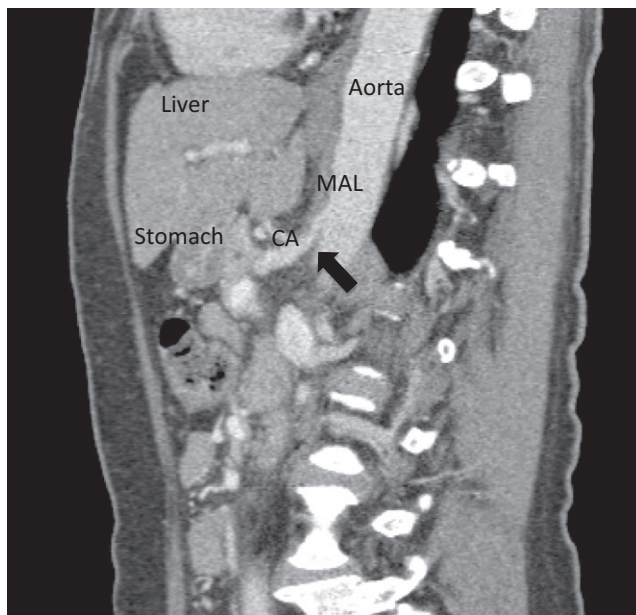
Contrast-enhanced CT indicated stenosis (arrow) on her origin of the celiac artery (CA) due to compression by the median arcuate ligament (MAL)
